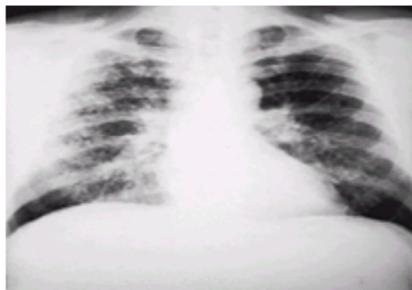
Radiograph of a subject with category 3/2, *q/r* simple CWP.
